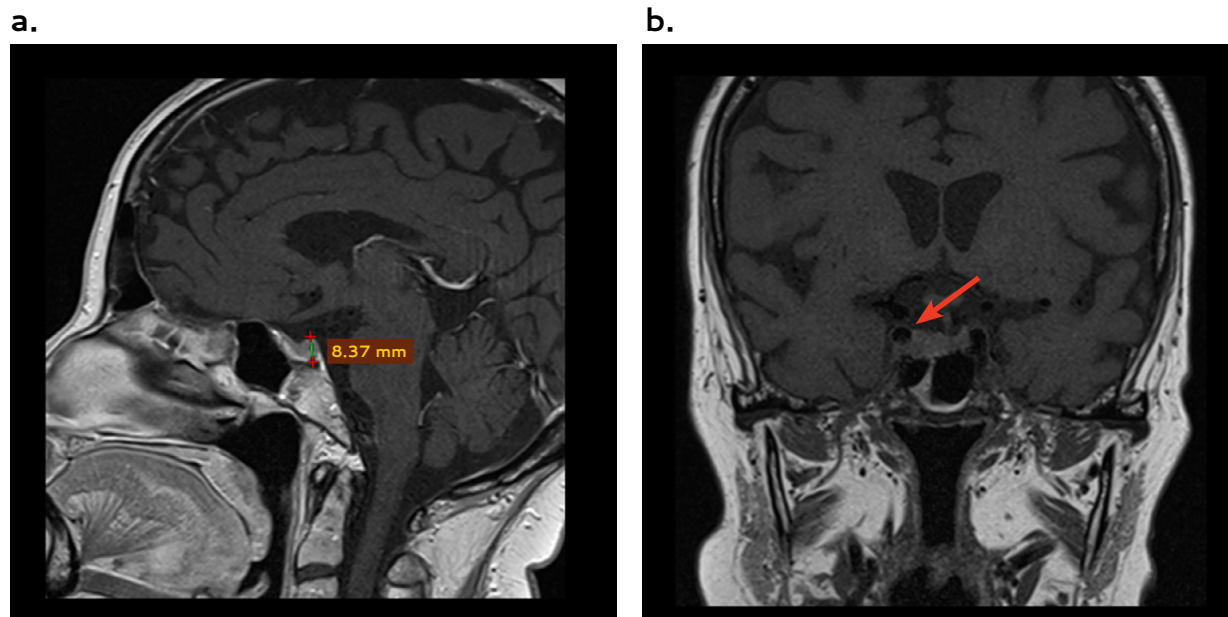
MRI of the sella turcica, T1 sequence
